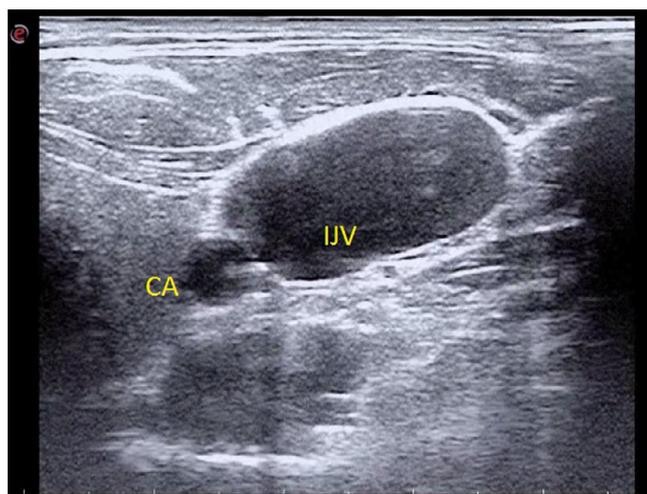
Ultrasound in a cross-sectional view showing venous stasis in the right internal jugular vein. CA, carotid artery; IJV, internal jugular vein.
